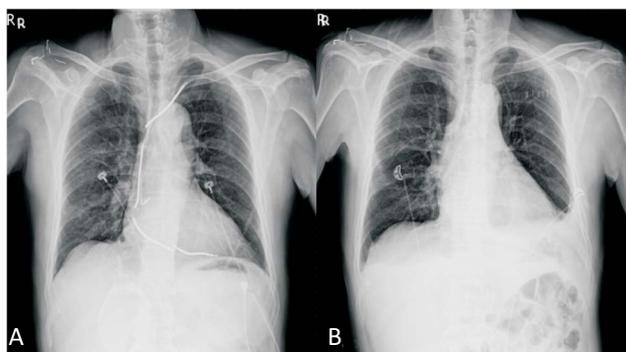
(A) Chest x-ray after removal of generator; (B) Chest x-ray after operation of pacing wire removal and tricuspid valve replacement.
